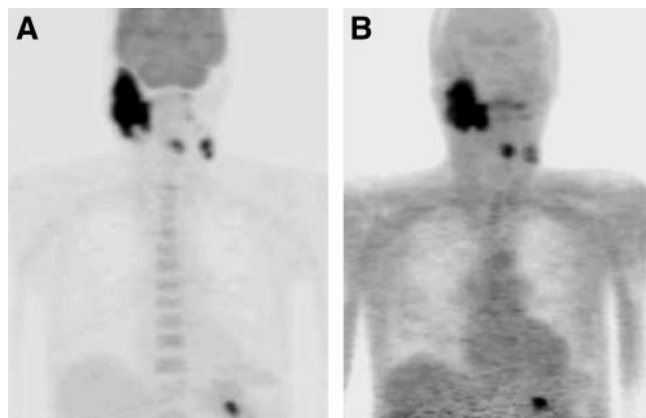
^{18}F -FDG PET (A) and ^{18}F -FET PET (B) of 63-y-old man (patient 32) with head–neck carcinoma (squamous cell carcinoma). Primary tumor and lymph node metastases are positive for both ^{18}F -FDG and ^{18}F -FET.
